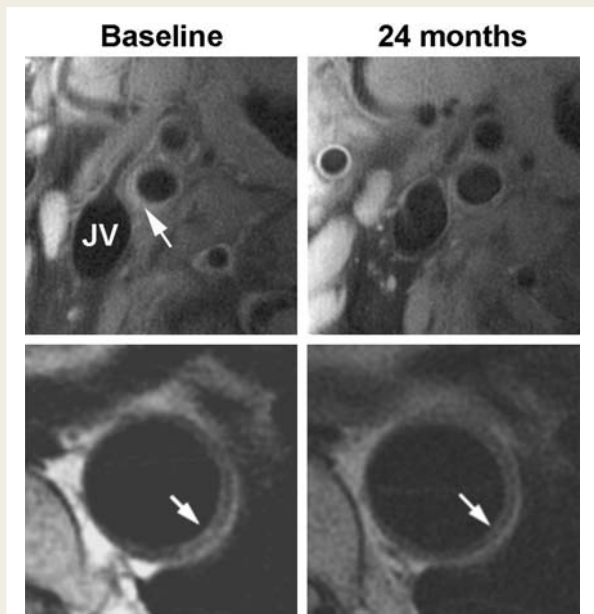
Matched magnetic resonance images of the right carotid bifurcation (upper panels) and the descending aorta (lower panels) in a hypercholesterolaemic patient at baseline and after 24 months of simvastatin therapy. A regression of the plaque (indicated by arrows) with small enlargement of the lumen is evident.^{37,69,71} JV, jugular vein.
